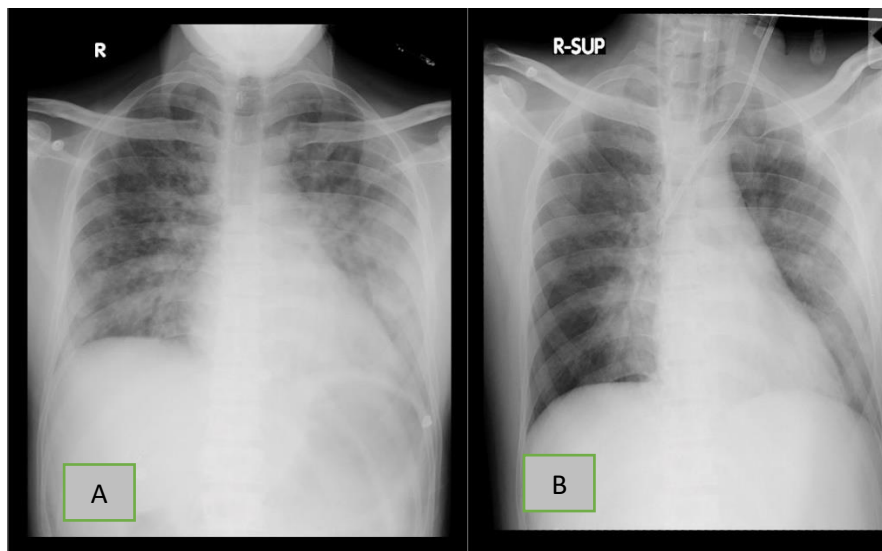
A- First X-ray showing evidence of pulmonary haemorrhage, B- serial x-ray showing resolution of pulmonary haemorrhage
